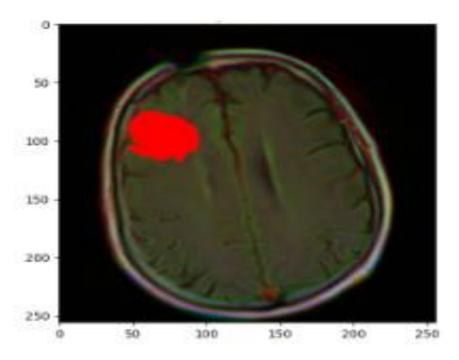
Brain MRI with original mask
